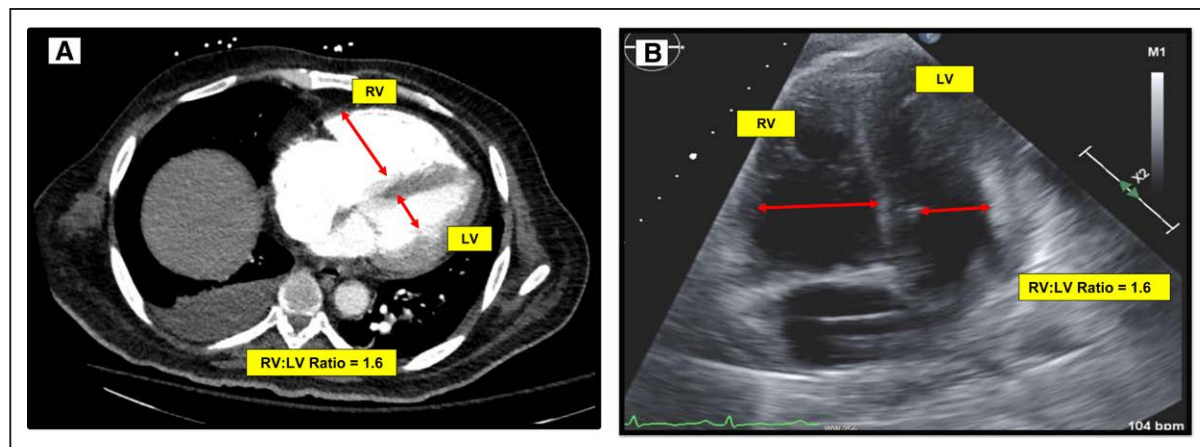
Acute RV dilation associated with pulmonary embolism as seen on CT and TTE.
